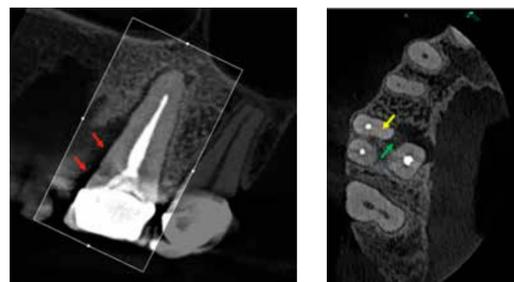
Oblique sagittal CBCT view of #3 with attenuation patterns suggestive of a narrow bony defect associated with the MB aspect of the P root of tooth #3 (red arrows)
